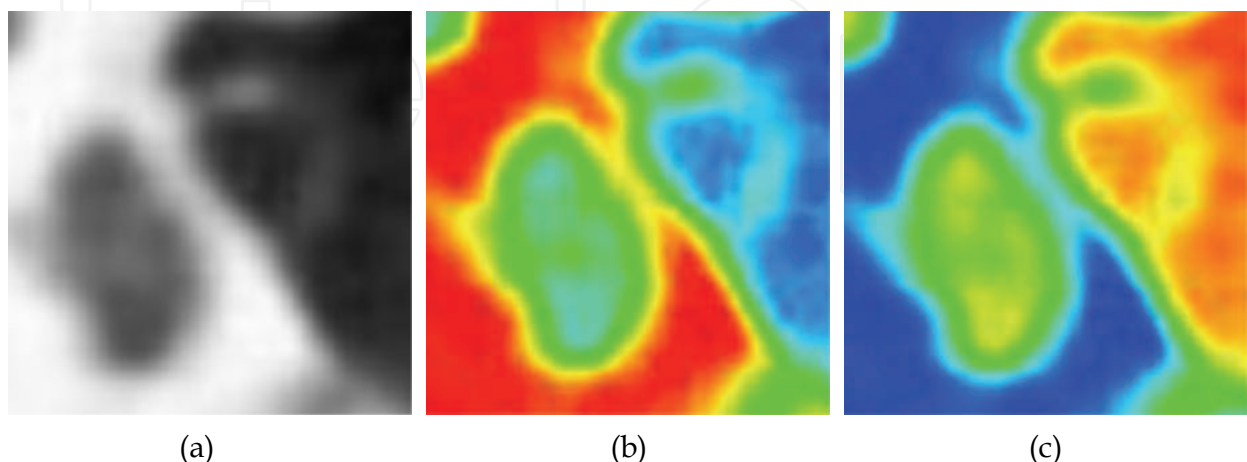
Axial image of CT showing pseudocolor transformation of stapes. a) plain image b) pseudocolor transformed image (red to blue) c) pseudocolor transformed image (blue to red)
